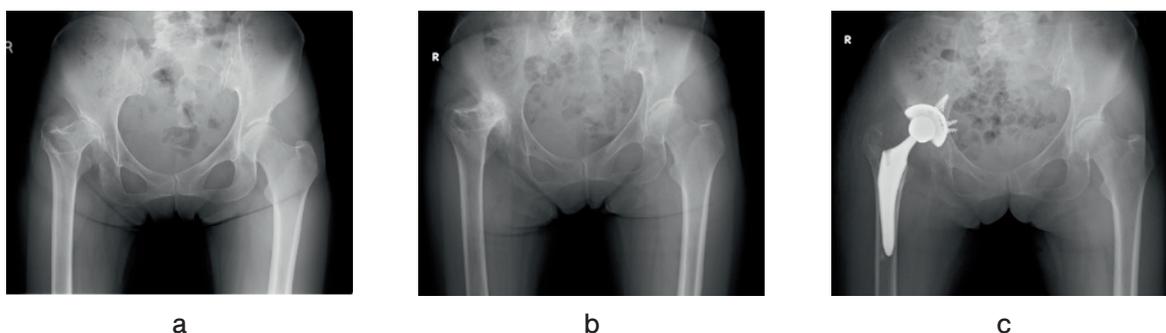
Simple radiographic (A-P) images of the patient’s hip joint at the time of (a) first visit in 2012, (b) before THR, and (c) after THR.
